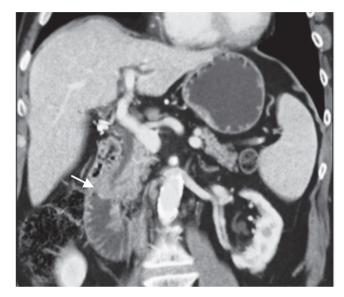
Computed tomography showed an ampullary mass with 13 mm suggestive of ampullary adenoma.
